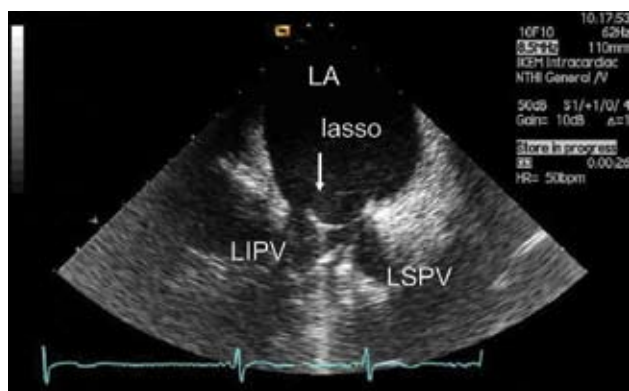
Intracardiac echocardiogram of the left atrium (LA) showing the Lasso catheter held in the proximal part of the vestibule. It is apparent that the Lasso is smaller than the diameter of the vestibule of left-sided veins (LIPV – left inferior and LSPV – left superior pulmonary vein, respectively).
